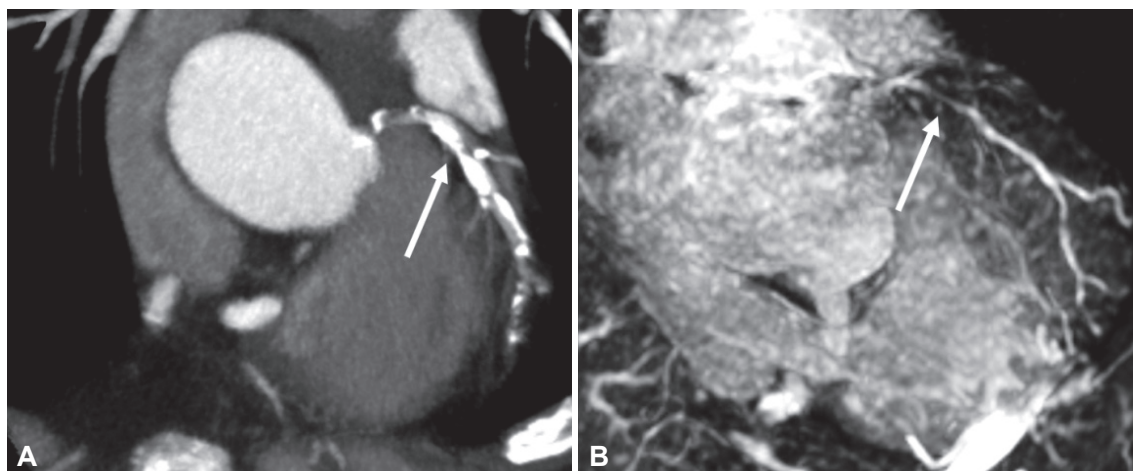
(A) Reformatted coronary CT angiography showing a heavily calcified proximal LAD plaque that prevented assessment of that segment (arrow). Coronary MRA of the same subject revealed significant stenosis in the region of the heavy calcification (B, arrow) that was confirmed on X-ray coronary angiography (not shown). LAD: left anterior descending, MRA: magnetic resonance angiography.
